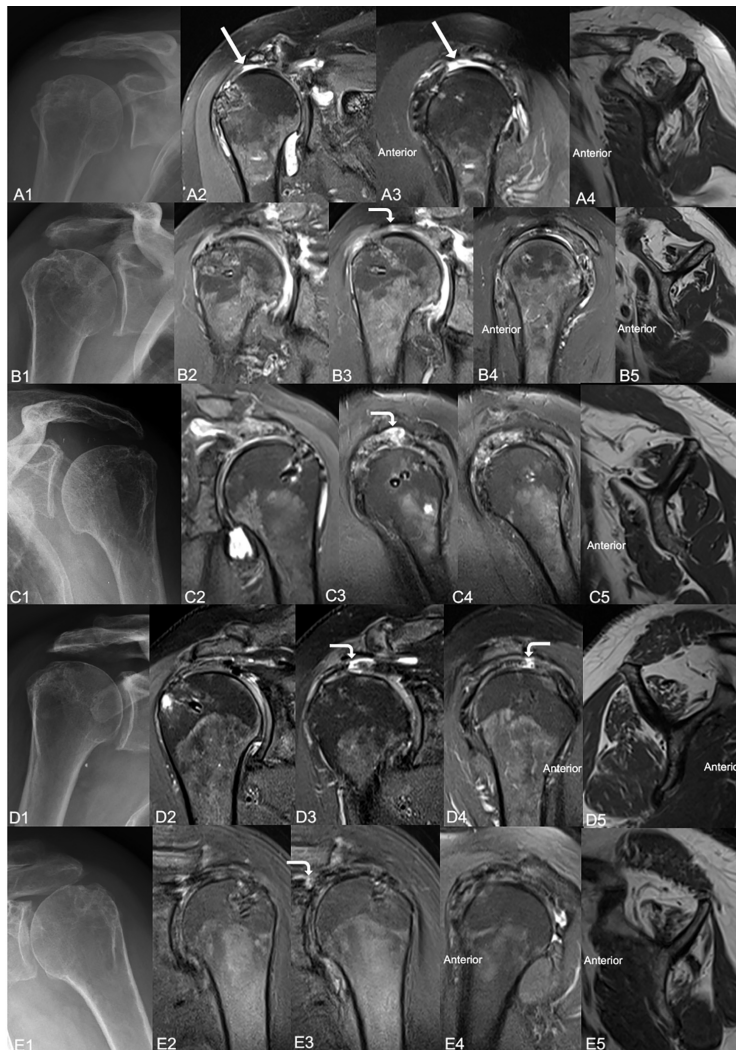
Imaging of patients who had a graft tear diagnosed at 3 years. (A1) True anteroposterior radiograph, complete graft tear (straight white arrow) on proton density fat-saturated (A2) coronal and (A3) sagittal magnetic resonance imaging (MRI) scans, and (A4) fatty degeneration of the rotator cuff muscles on T1-weighted sagittal MRI scan of the right shoulder of patient 1. (B1) Glenohumeral articular cartilage degeneration on true anteroposterior radiograph, no graft tears on proton density fat-saturated (B2) coronal and (B4) sagittal MRI scans, (B3) small tear or suture hole (curved white arrow) on 1 cut of proton density fat-saturated coronal MRI scan, and (B5) fatty degeneration of the rotator cuff muscles on T1-weighted sagittal MRI scan of the right shoulder of patient 12. (C1) True anteroposterior radiograph, no graft tears on proton density fat-saturated (C2) coronal and (C4) sagittal MRI scans, (C3) small tear or suture hole (curved white arrow) on 1 cut of proton density fat-saturated sagittal MRI scan, and (C5) fatty degeneration of the rotator cuff muscles on T1-weighted sagittal MRI scan of the left shoulder of patient 14. (D1) Glenohumeral articular cartilage degeneration on true anteroposterior radiograph, (D2) no graft tear on proton density fat-saturated coronal MRI scan, small tear or suture hole (curved white arrow) on proton density fat-saturated (D3) coronal and (D4) sagittal MRI scans, and (D5) fatty degeneration of the rotator cuff muscles on T1-weighted sagittal MRI scan of the right shoulder of patient 17. (E1) True anteroposterior radiograph, no graft tear on proton density fat-saturated (E2) coronal and (E4) sagittal MRI scans, (E3) small tear or suture hole (curved white arrow) on 1 cut of proton density fat-saturated coronal MRI scan, and (E5) fatty degeneration of the rotator cuff muscles on T1-weighted sagittal MRI scan of the left shoulder of patient 19.
